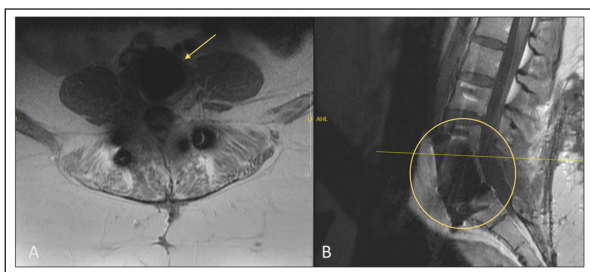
Follow-up. Latest follow up MRI (A) axial and (B) sagittal 3 years post-op showing no evidence of any local recurrence (yellow circle and arrow).
